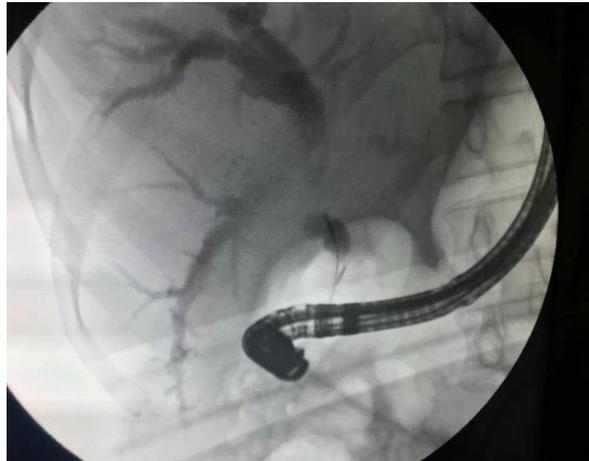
X-ray view showing a choledoccal stone with dilation of the proximal part of the main bile duct and both right and left bile ducts
